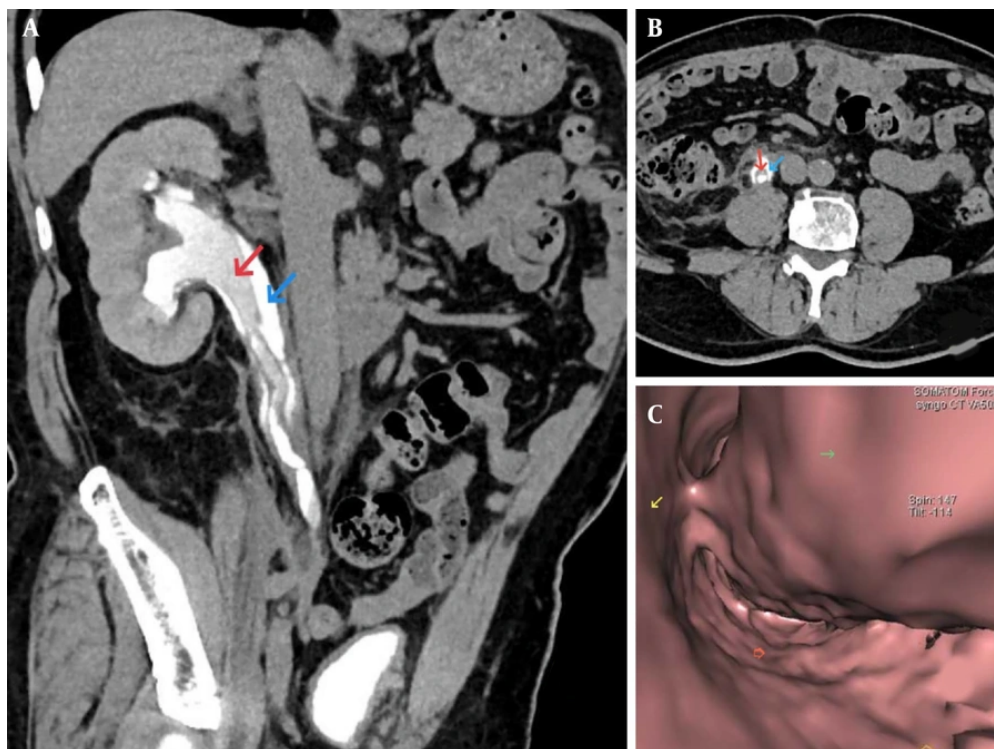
CT urography: A and B, During the contrast excretion phase, the middle to upper ureter shows a double-lumen appearance, with separation of the luminal structure (red arrow: ureter; blue arrow: ureteral dissection). CT virtual endoscopy: C, Ureteral dissection (green arrow: ureteral mucosa; yellow arrow: ureteral muscularis; arrowhead: ureteral dissection).
